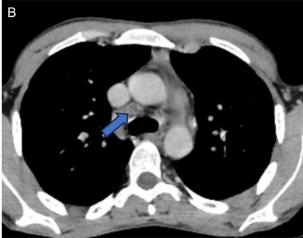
(A, B) CT axial slice in parenchymal window showing some pulmonary nodules and micromodules in the lung parenchyma(star), as well as mediastinal lymphadenopathy with necrotic center (arrow).
